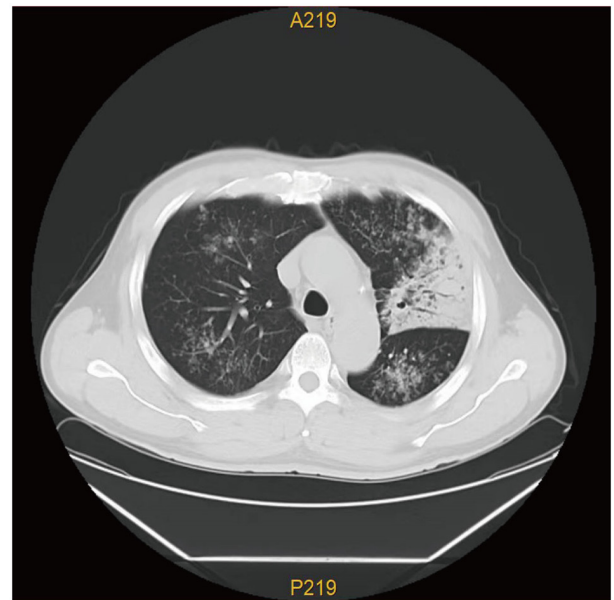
CT scan demonstrating multiple patchy, nodular and tree-in-bud opacities in both lungs, especially the left lung.
